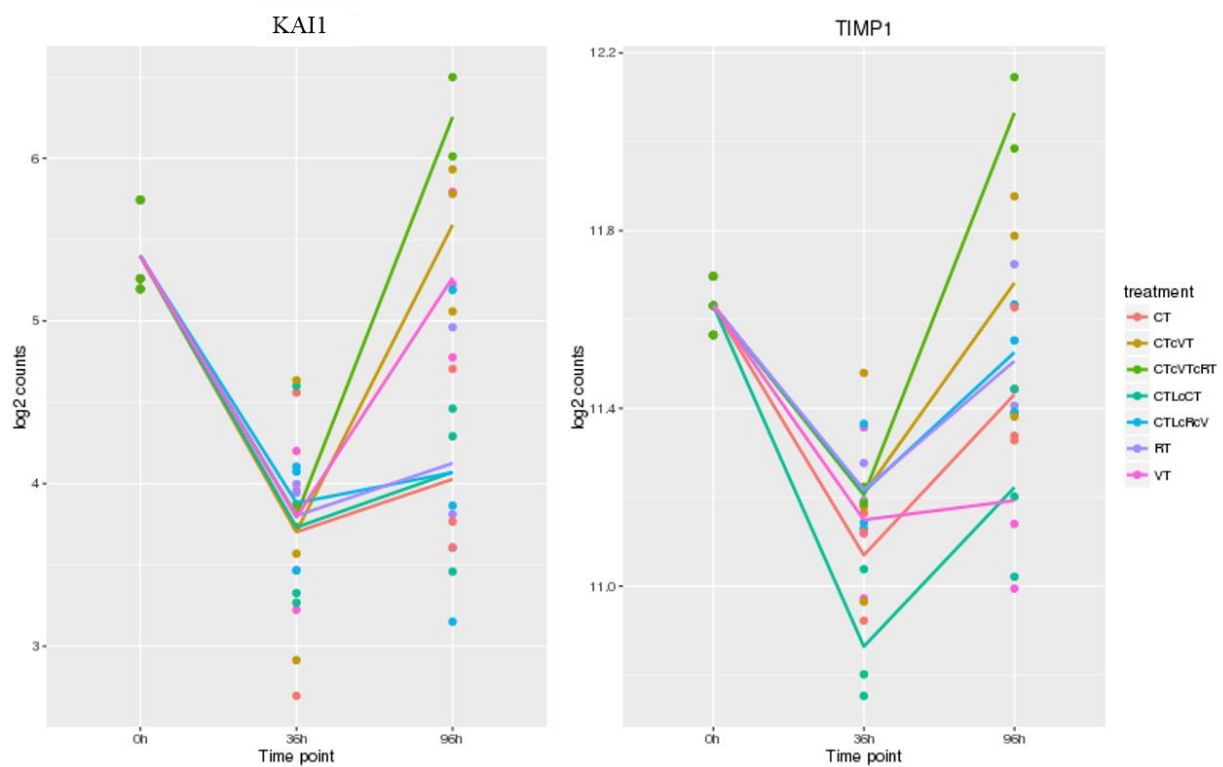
Coherent increase in KAI1 and TIMP1 transcripts in CT-VT-RT treated cells. RNASeq revealed increased mRNA expression of KAI1 (left) and TIMP1 (right) in CT-VT-RT (green) treated LN2308 cells at 96 hpt. The mRNA transcripts are expressed as log₂ counts (Y-axis) at different time points (X-axis).
